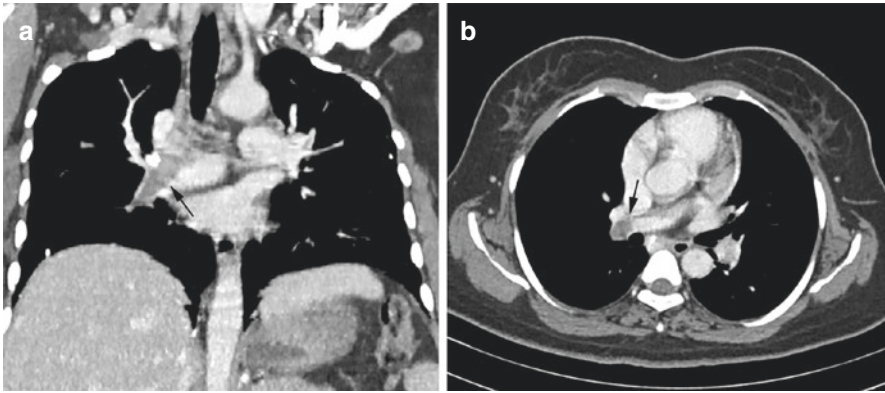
Pulmonary thromboembolism in patient with endometrial carcinoma. (a) coronal, and (b) axial contrast enhanced CT images shows right pulmonary artery intraluminal filling defect suggestive of pulmonary thromboembolism
